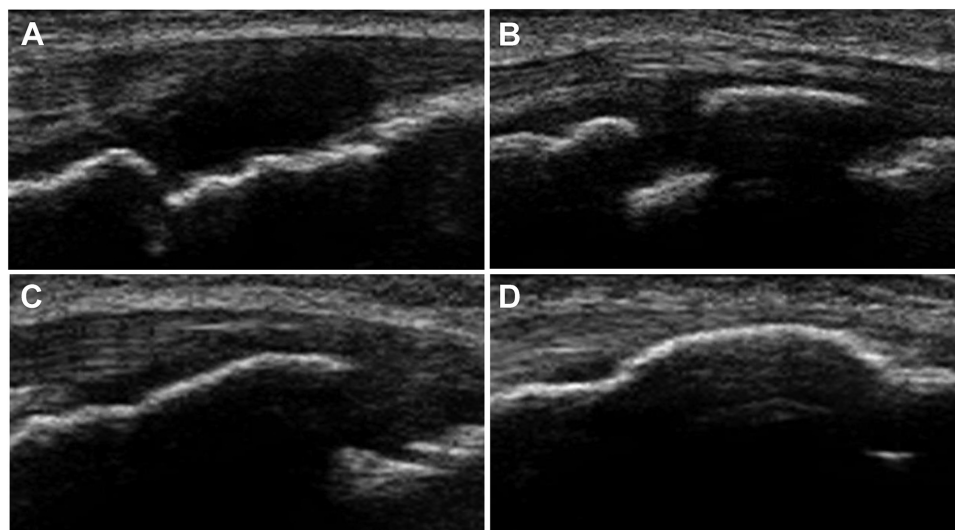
Ultrasound images showing various stages of tibial tuberosity maturity. (A) Cartilage stage: a large amount of apophyseal cartilage. (B) Apophyseal stage: the presence of a secondary ossification center. (C) Epiphyseal stage: no detectable distinction between the secondary ossification center and the tibial epiphysis. (D) Bony stage: no epiphyseal line.
